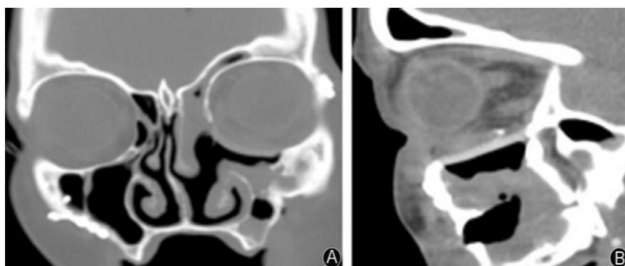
A: Coronal CT scan taken 5 weeks after surgery shows significant implant adaptation to the mesial wall; B: Sagittal CT scan taken 5 weeks after surgery shows significant implant adaptation to the posterior stop.
